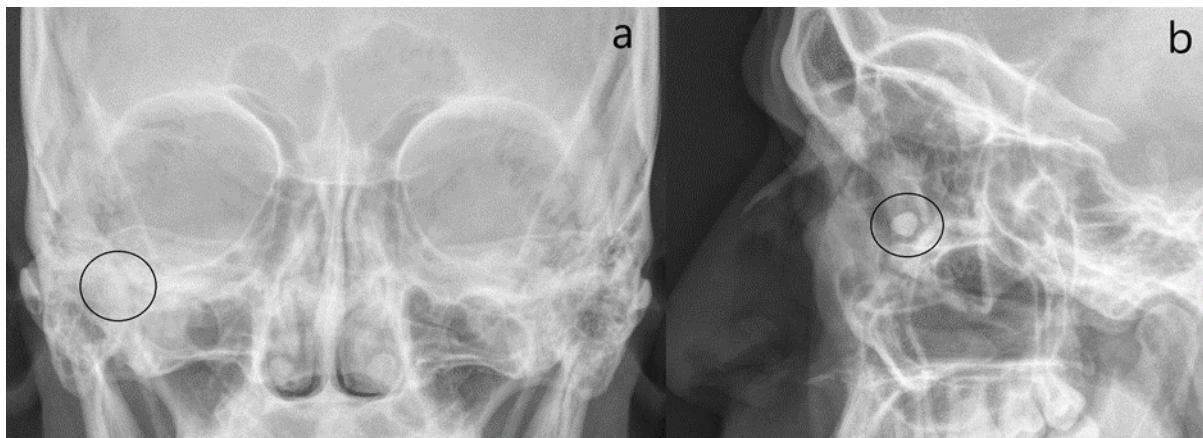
X-ray Orbit showing foreign body in right orbit (a) AP (b) Right Lateral view.
